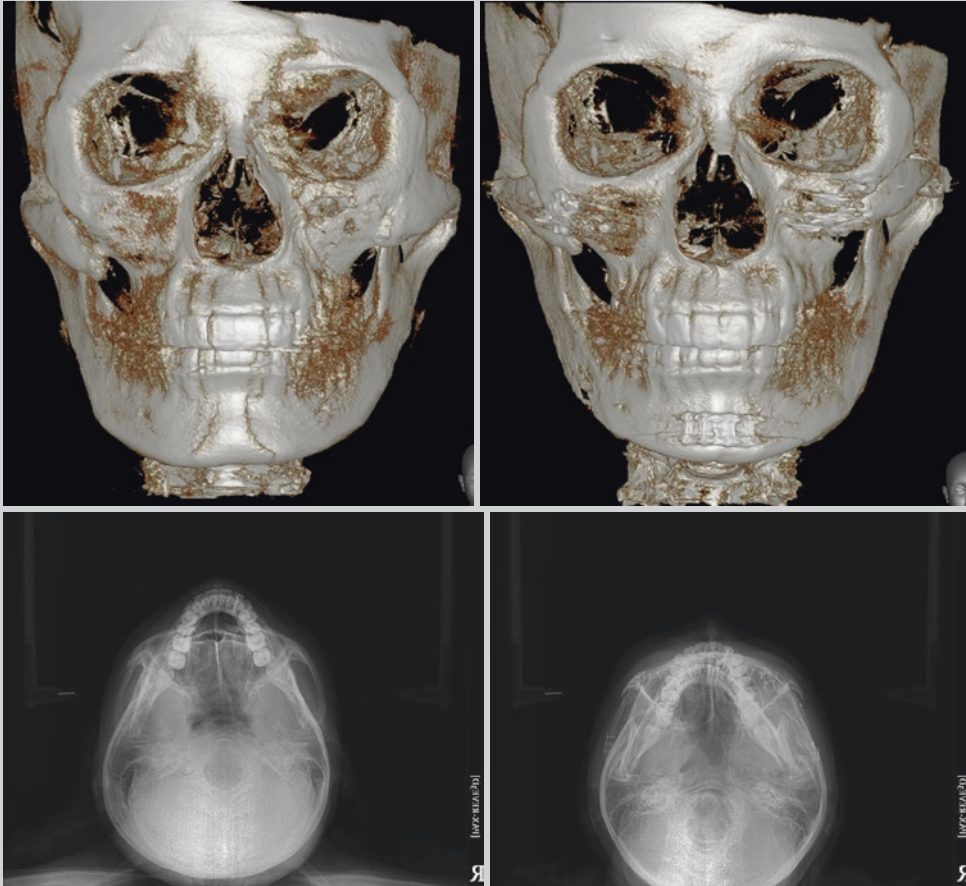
(Above, left) Preoperative three-dimensional CT scan. (Above, right) Postoperative three-dimensional CT scan. (Below, left) Preoperative basal
